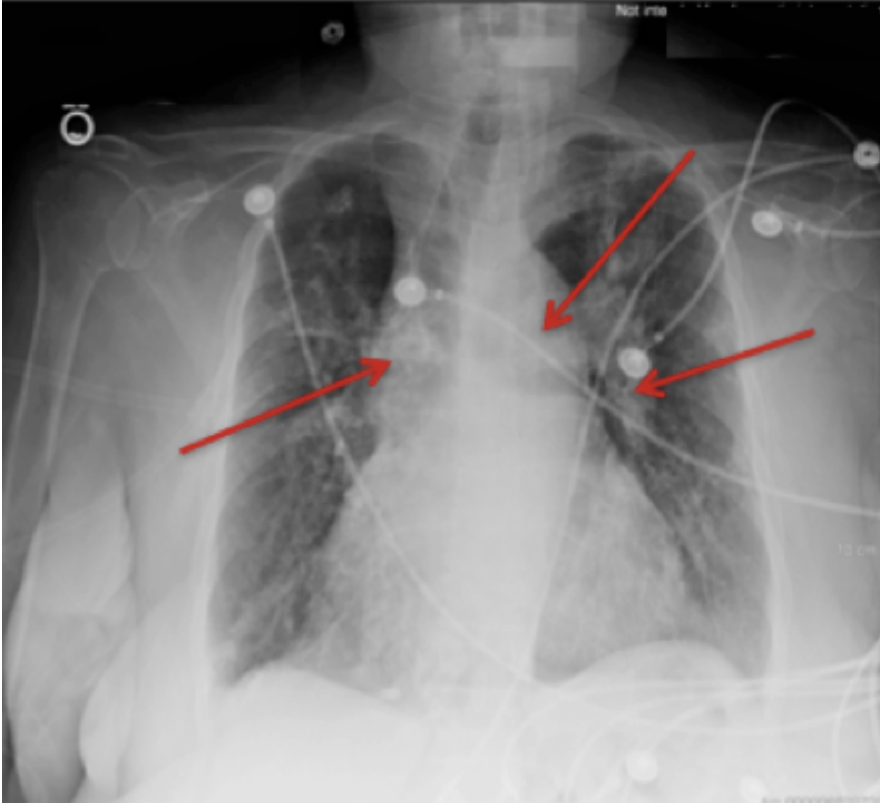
Chest radiograph with the 2 arrows on either side of the sternum pointing to an enlarged hilar lymph node and the central arrow pointing to aneurysmal dilation of the ascending aorta.
